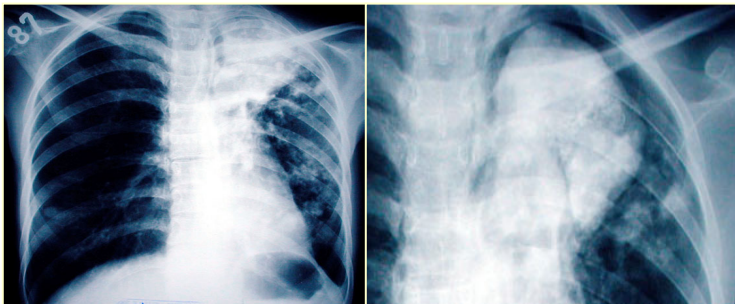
Chest X-ray showing fibrotic infiltrate and cavity with a fungus ball in the upper left lobe.
